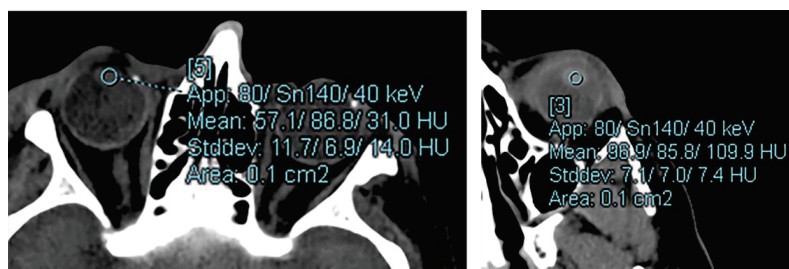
A representative example of how ROI measurements were obtained for the study. All measurements were obtained in the axial plane using 1 mm thick slices. ROI data was obtained using the default syngo.via Monoenergetic+ application. All scans were non-contrast dual-source, dual-energy CT exams. See the text Section 2.2. for the DECT acquisition parameters.
